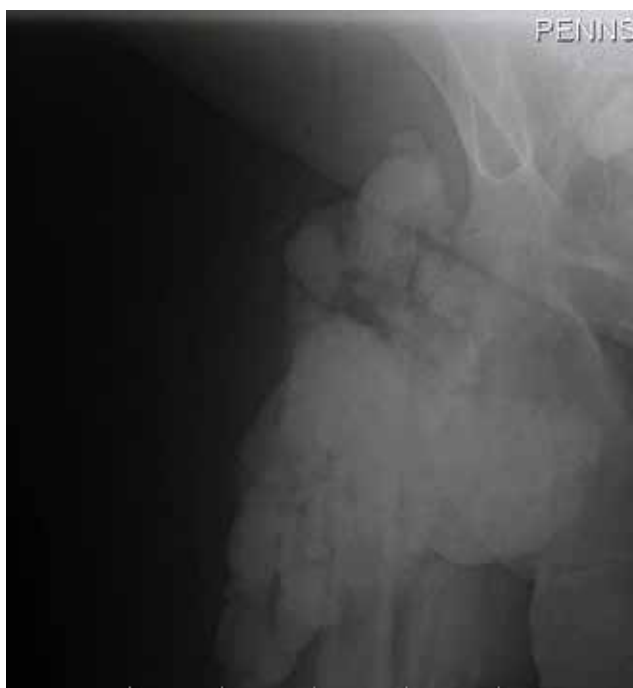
Plain radiograph of right hip shows soft-tissue calcifications preventing optimal visualization of cortical borders of proximal femur.
